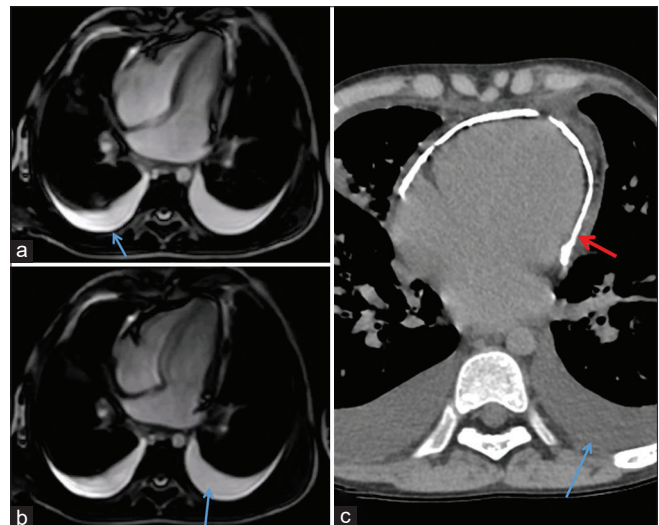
Constrictive pericarditis. Four-chamber image in diastole (a) and systole (b) showing elongated ventricles with extrinsic restriction to relation and dilated atria. (c) Computed tomography scan showing diffuse pericardial calcification (red arrow). Also seen are bilateral pleural effusions (blue arrows)
